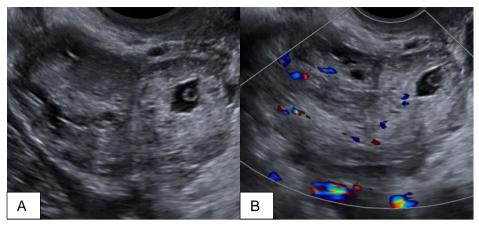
A 34-year-old patient with a positive pregnancy test comes to the emergency department complaining of pelvic pain. Transvaginal ultrasound is performed (images A and B) where an image with ring morphology is identified, dependent on the right ovary and which shows a gestational sac inside, with no evidence of cardiac activity; findings consistent with ovarian ectopic pregnancy.
